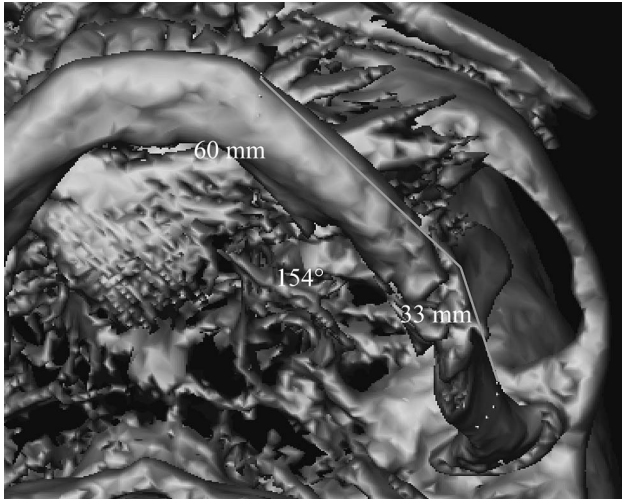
Three-dimensional computed tomography scan demonstrates preoperative virtual planning of mandibular osteotomy lines as well as shape and length of the bone graft to be harvested.
